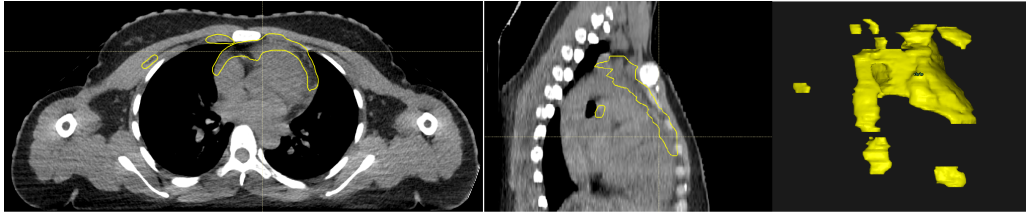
left: Axial CT view of patient 17, with the CTV delineated. Middle: Sagittal view of the same patient. Right: 3D render of the CTV, anterior view. This patient’s CTV spans lymph nodes from the height of the clavicle down to the caudal part of the sternum, including some interpectoral lymph nodes. It consists of 9 separate volumes, the largest of which covers the anterior part of the heart.
